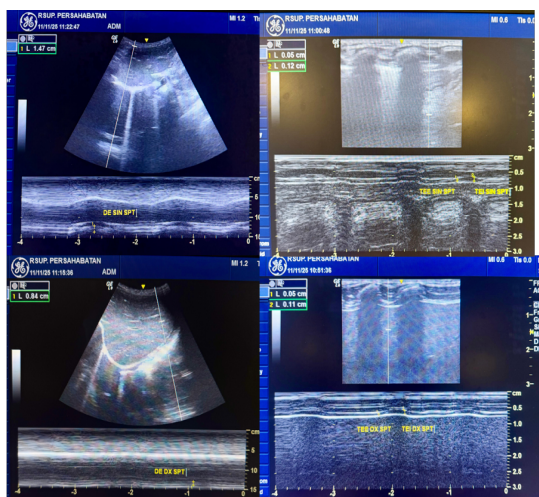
Case III: Diaphragm ultrasonography showing normal and functional diaphragm (12/11/25)
